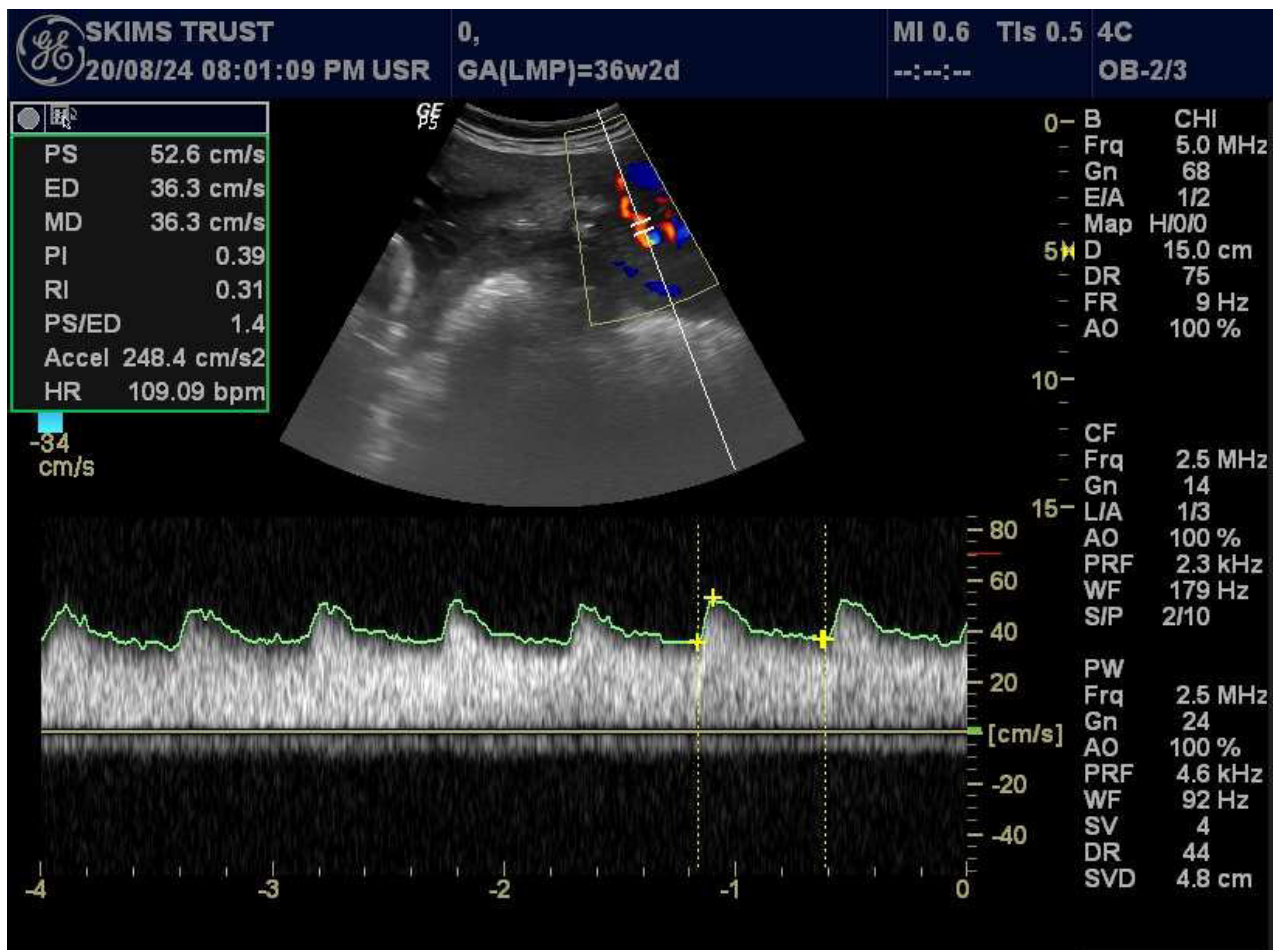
Uterine artery doppler waveform showing a normal low-resistance flow pattern.
